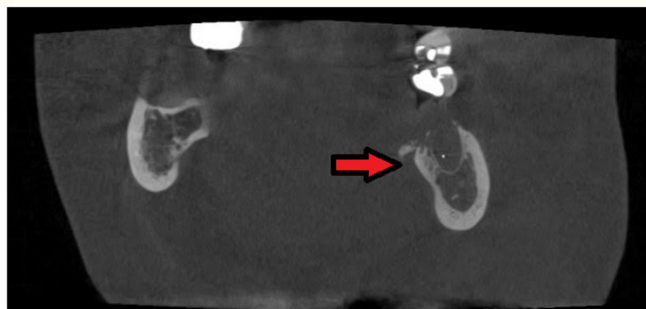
View of coronal section in Cone Beam CT, alveolus area piece 30 with free fragments and restorative material that contaminates the area.
